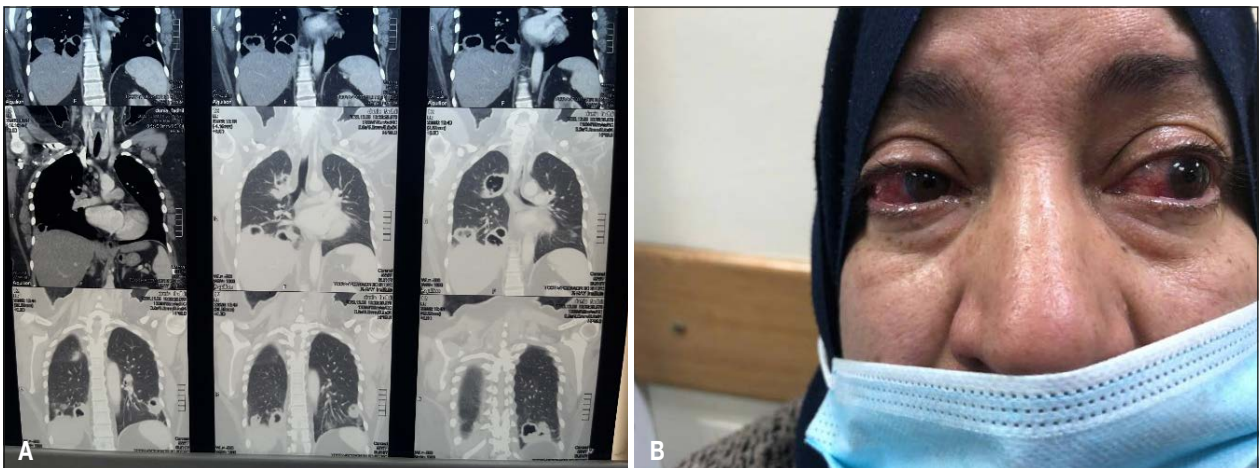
A) Computed tomography scan showing multiple cavitory lesions of the lungs surrounded by minimal consolidation; B) photo of the patient's eyes at admission.
